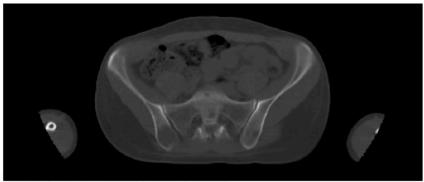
Transaxial CT image in pelvic bones
